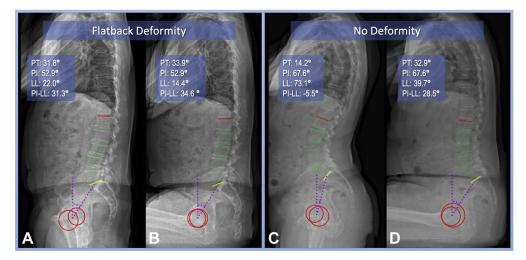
Sitting and standing radiographs in a patient with flatback deformity and a patient without flatback deformity including measurements of PT, PI, LL, and PI-LL. (A and B) Sitting and standing lateral radiographs of a patient with flatback deformity. (C and D) Sitting and standing lateral radiographs of a patient with no deformity. Patients with flatback deformity were found to have a smaller change in spinopelvic parameters when going from sitting to standing.
